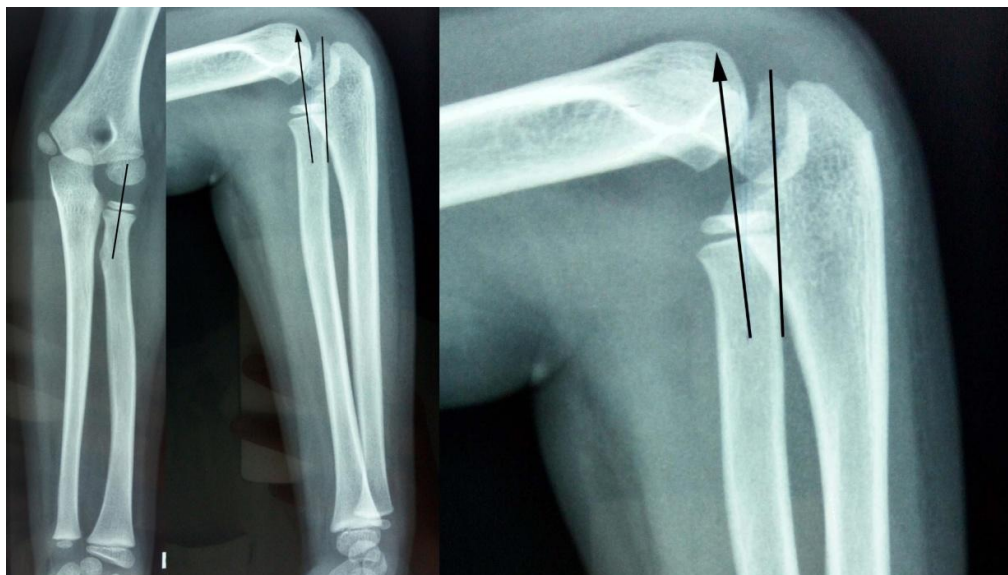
Plain radiographs of the left elbow and forearm showed a disrupted radio-capitellar line (arrow-headed line). It should pass through the long axis of the radial neck and point towards the center of the capitellum (plain line). There was no radius or ulna fracture or plastic deformity
